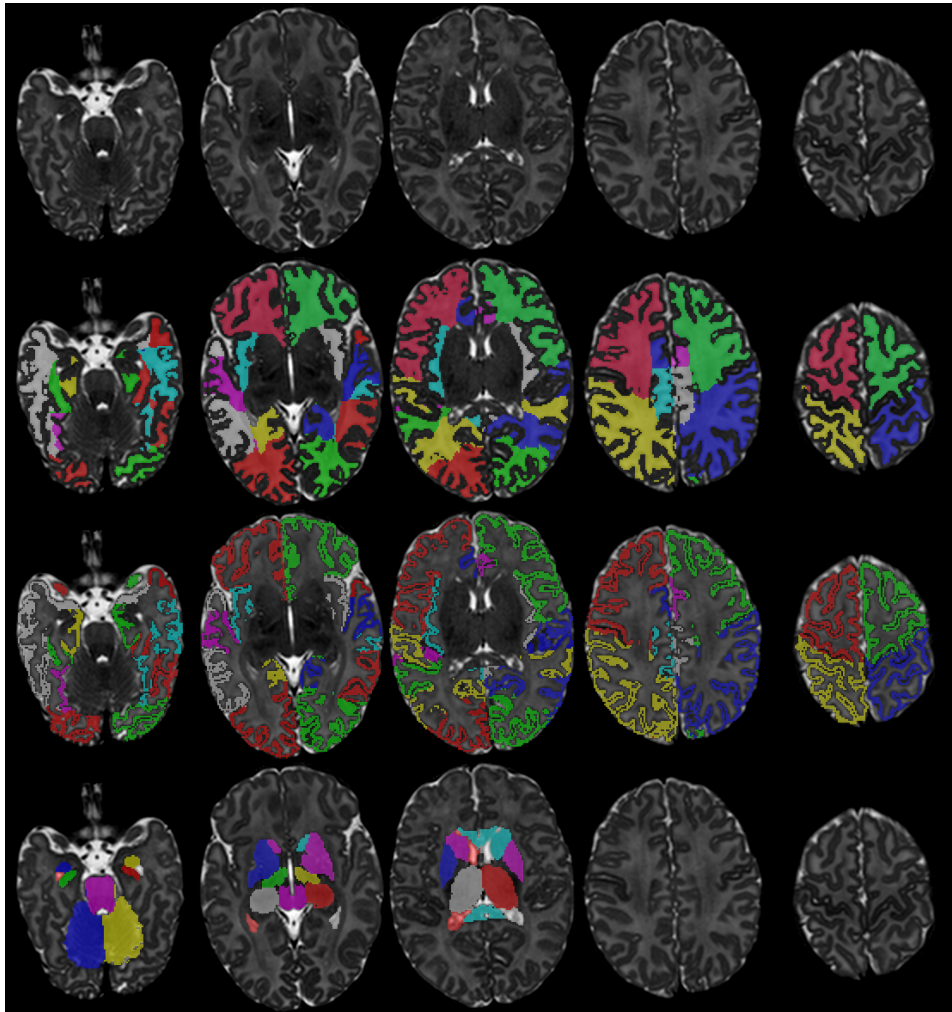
Example segmentation of a neonatal MRI acquired at 44 weeks age at scan with the 82 labels overlaid (second row: WM labels, third row: CGM labels, fourth row: subcortical GM labels and ventricles).
